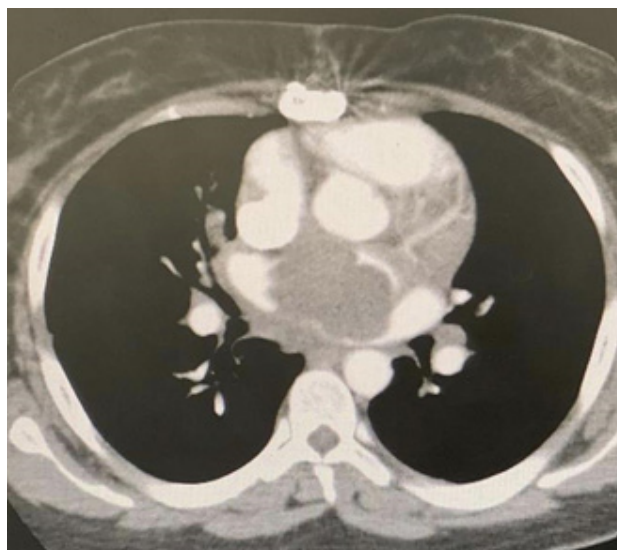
Computed Tomography Exam showing heart region before chemotherapy
